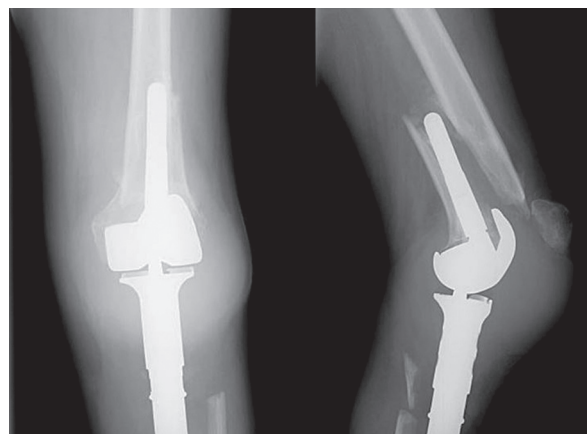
Radiographs of the femur (periprosthetic fracture)
